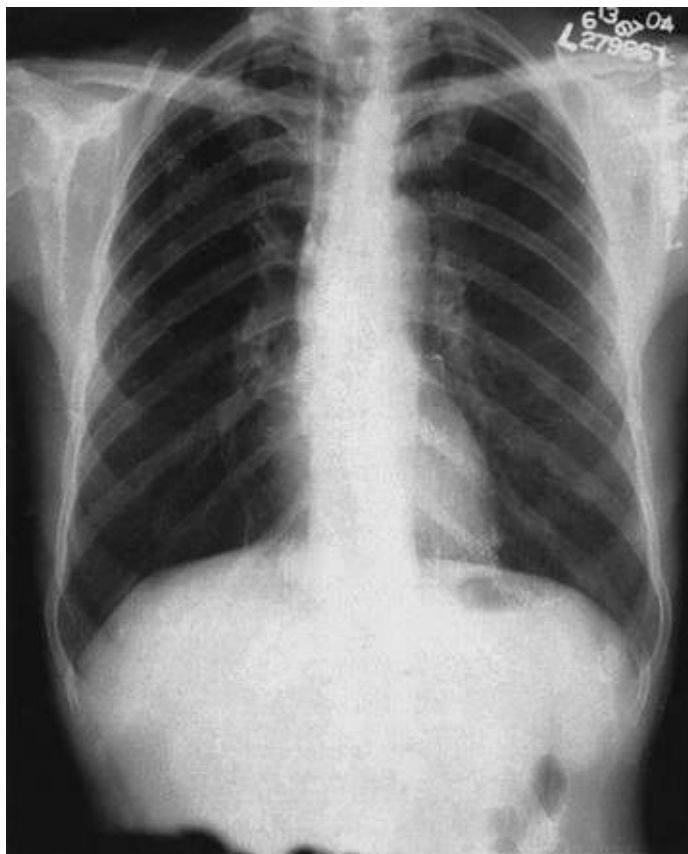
Routine chest radiograph of a patient with Addison disease related to tuberculosis. In addition to the small cardiac silhouette, calcified lymph nodes are present in the hilum of the right lung. (Courtesy Dr. J.B. Naidich.)
